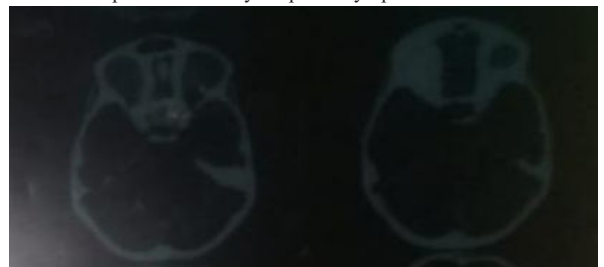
CT scan showing homogenous soft tissue in right and left extraconal compartment superiorly placed. The lesion is limited to extraconal compartment. Bilateral proptosis is present.
